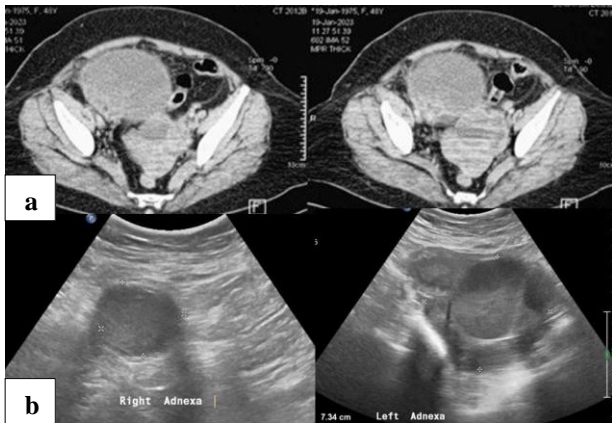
(a) CT scan showing bilateral complex adnexal lesions; right being larger than left; and (b) US abdomen after 6 months showing significant reduction in the size of right adnexal lesion and mild increase in the size of left adnexal lesion with a dilated tubular structure alongside.
